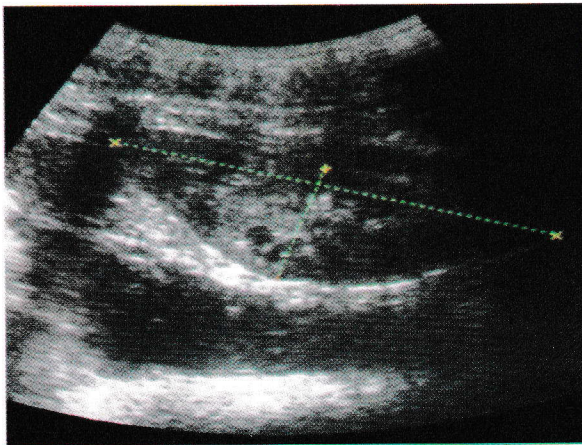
Abdominal sonogram showing the right kidney with normal anatomy and echopattern.
